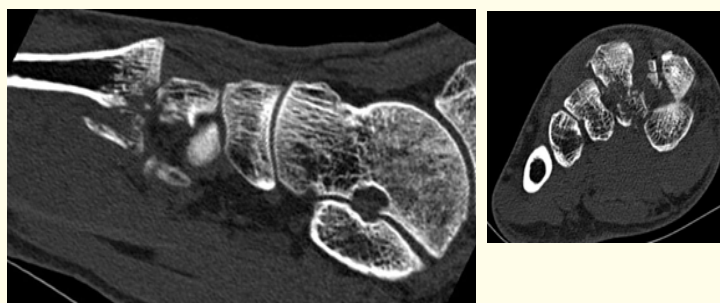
CT scan with complex fracture dislocation of base of the 2nd ray, separation between the 1st and 2nd metatarsal and comminuted fractures of the cuneiforme II.
